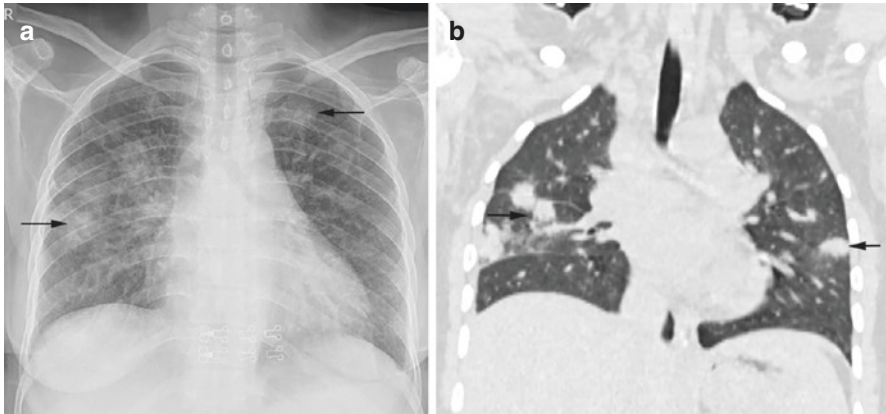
Fungal pneumonia in a patient with AML. (a) Chest radiograph, PA view, and (b) coronal chest CT, lung window, shows multiple nodules (black arrows) in bilateral lungs with peripheral ground glass opacity s/o halo sign
